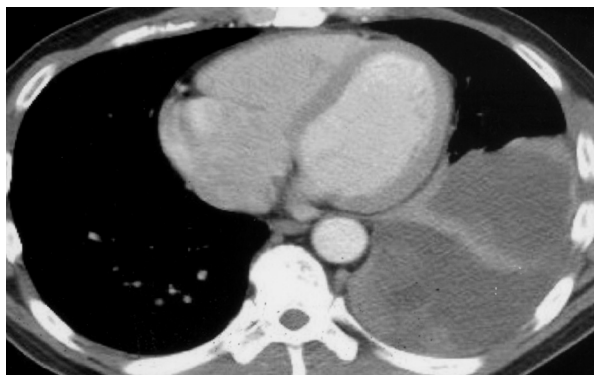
Computed tomographic scan of the chest disclosed a pleural mass at the left lower hemithorax.
